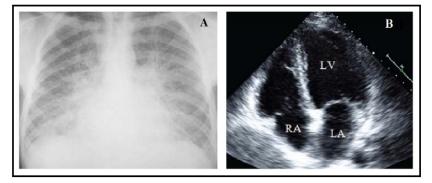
A. Chest X-Ray showed Cardiomegaly with Acute Pulmonary Edema, B. 2D Echo revealed dilated Left Ventricle with systolic dysfunction
